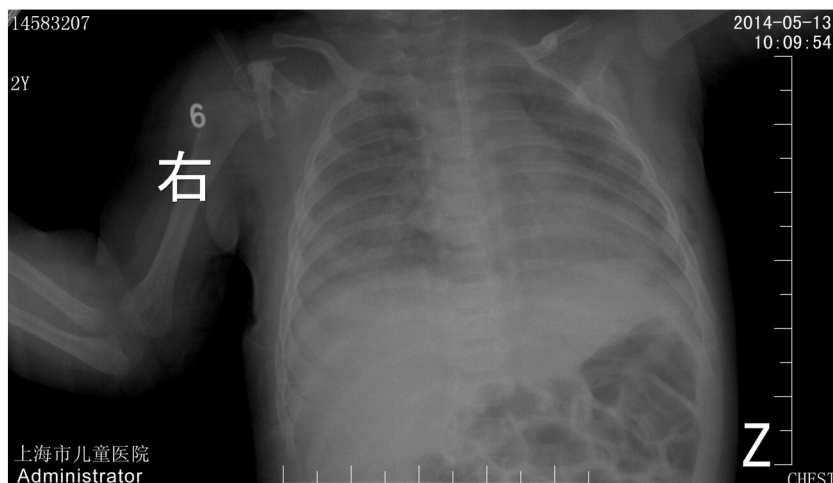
Chest X-ray After chelated treatment.
